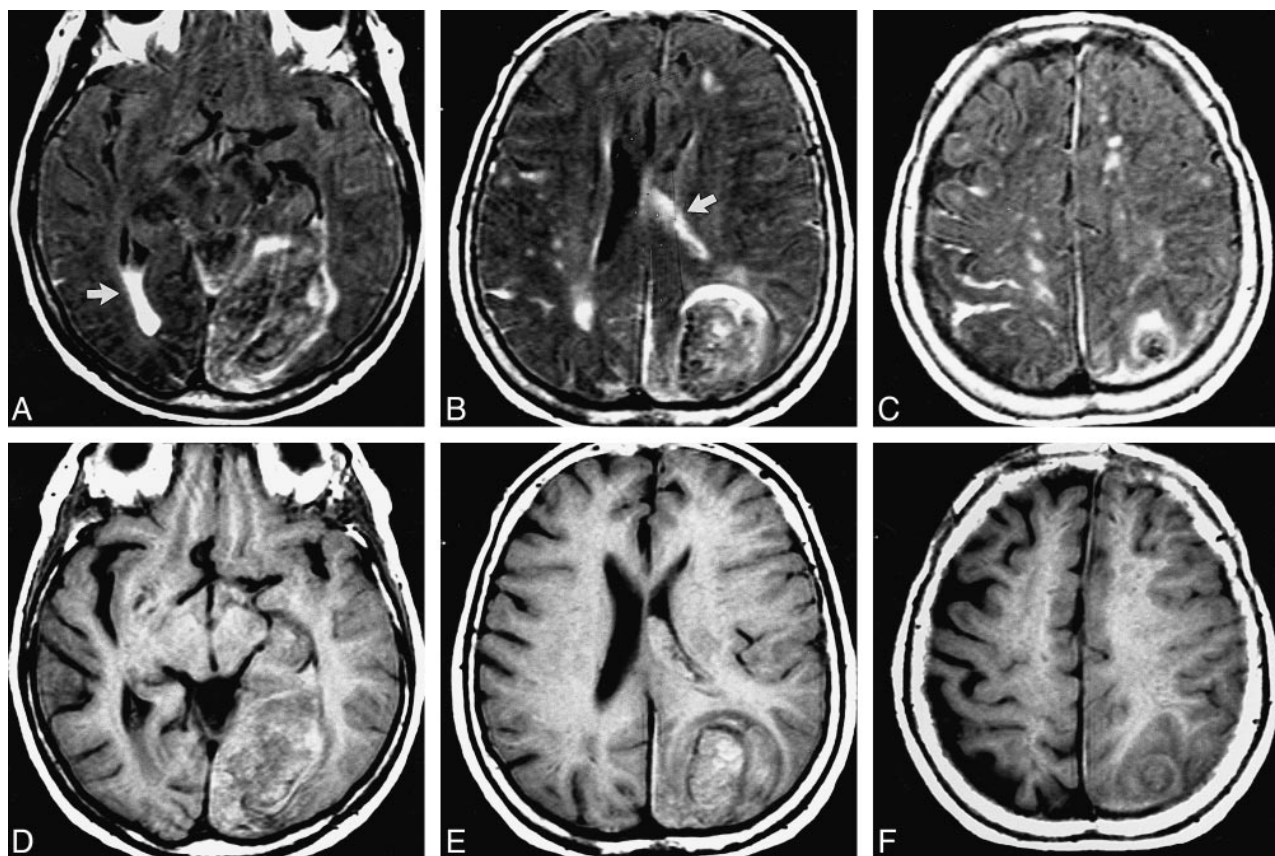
Case 2: 79-year-old woman with acute IVH, intraparenchymal hemorrhage, and SAH who had imaging on the day of ictus. MR and CT studies were obtained 2 hours apart. The FLAIR images show the IVH and SAH better than the T1- and T2-weighted images or the CT scans do.
